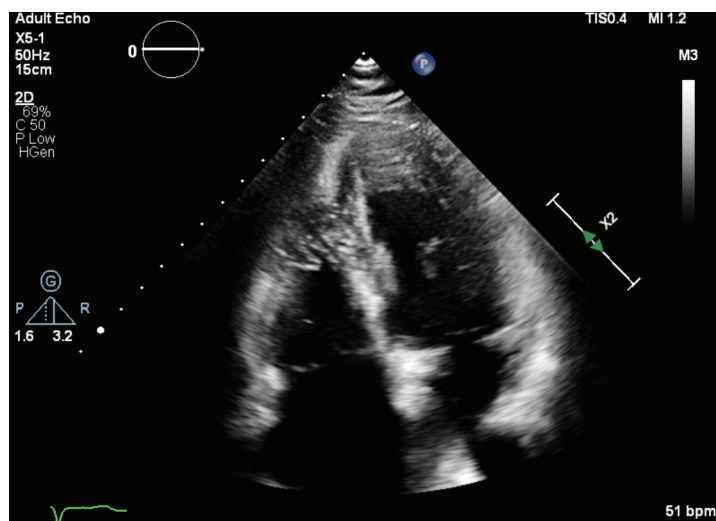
Apical 4-chamber view focused on the right ventricle.
